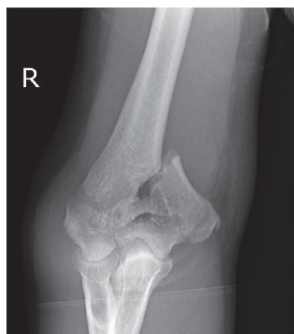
Lateral radiograph supracondylar fracture elbow
